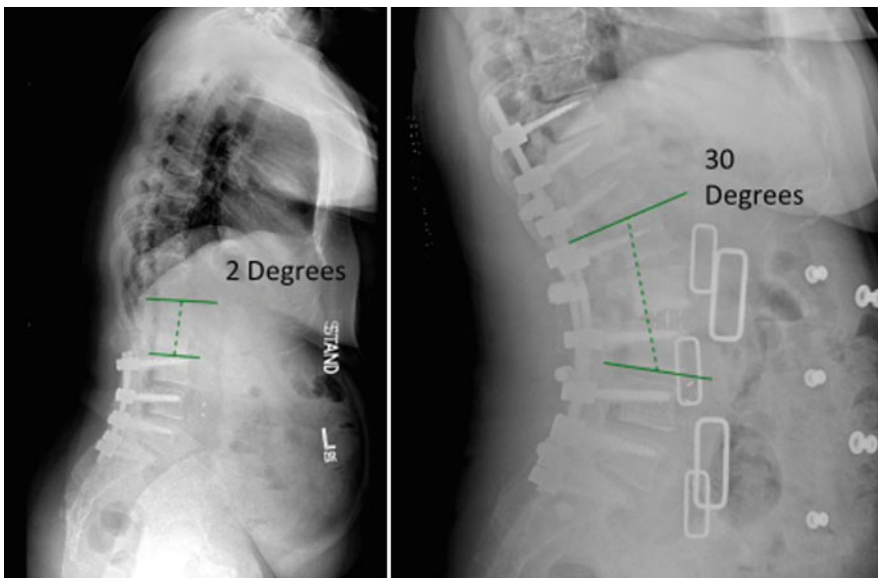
A 63-year-old patient presented with global sagittal imbalance and stenosis at L2–L3. Initial radiographs on left demonstrate segmental lumbar lordosis measuring at 2° from L2 to L3. Radiographs on right demonstrate
